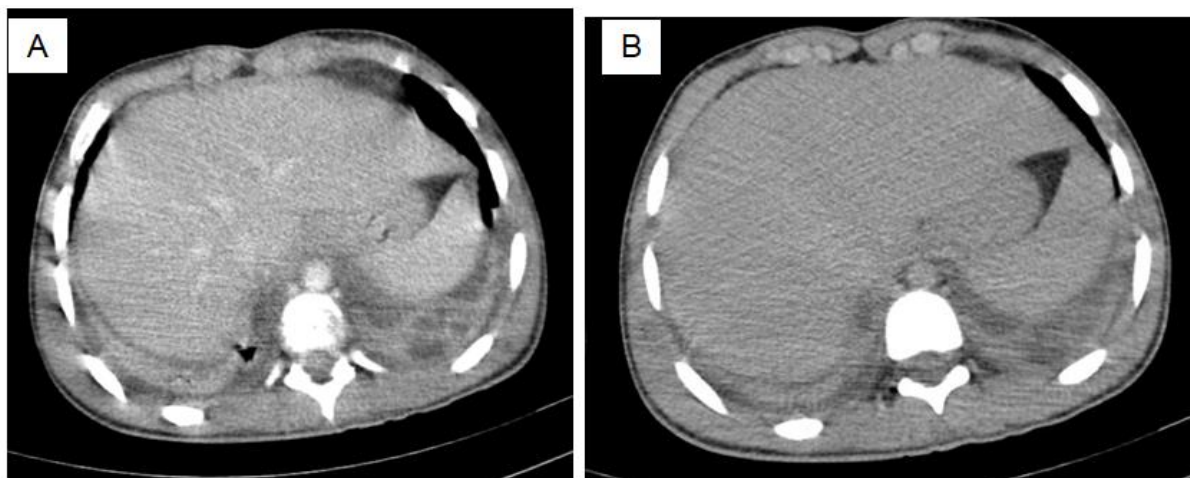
Axial chest CT scan mediastinal window with (A) and without contrast injection (B) shows bilateral basal cystic lesions, some of which are confluent, with enhanced walls after contrast injection, along with bilateral pleural effusion
